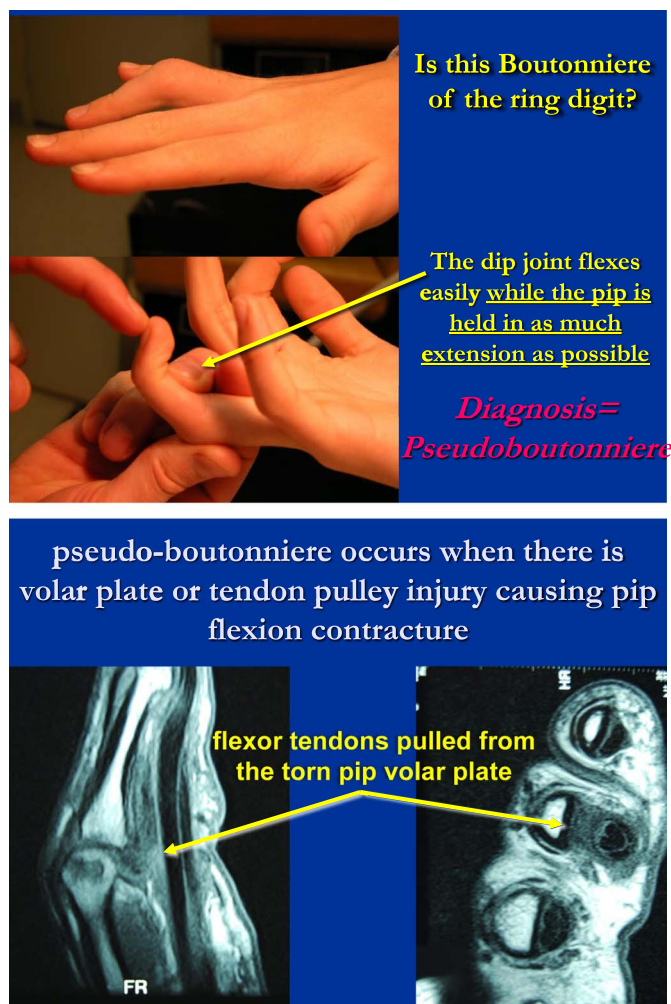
A, Negative Boyes test can rule out Boutonniere deformity when DIP passively flexes easily while PIP is as extended as possible. Diagnosis is pseudo-Boutonniere deformity due to flexor injury as seen on MRI (B).
